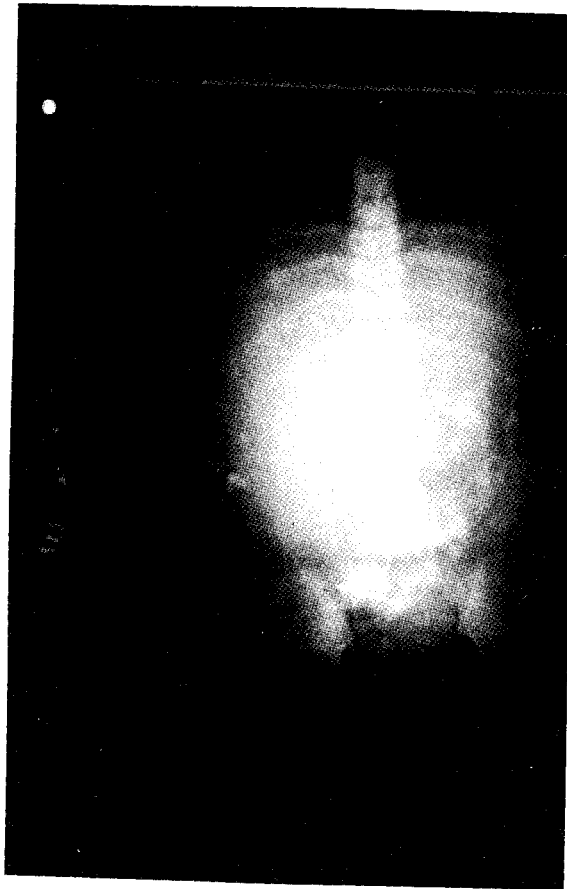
Plain x-ray of the abdomen showing diffuse calcifications.
